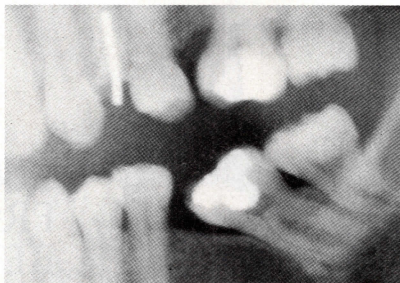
Close-up of left side preorthodontic radiograph, showing variation in degrees of molar collapse, residual molar space, and angular crest formation between upper and lower quadrants.
